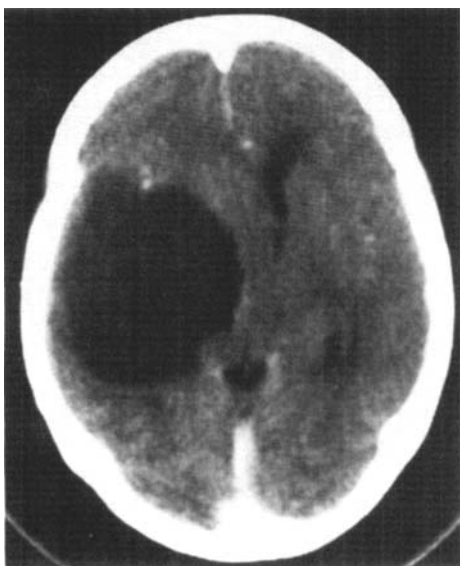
CT in 1988 showing a huge roundish non-enhanced hypodense lesion in the right temporal lobe.
